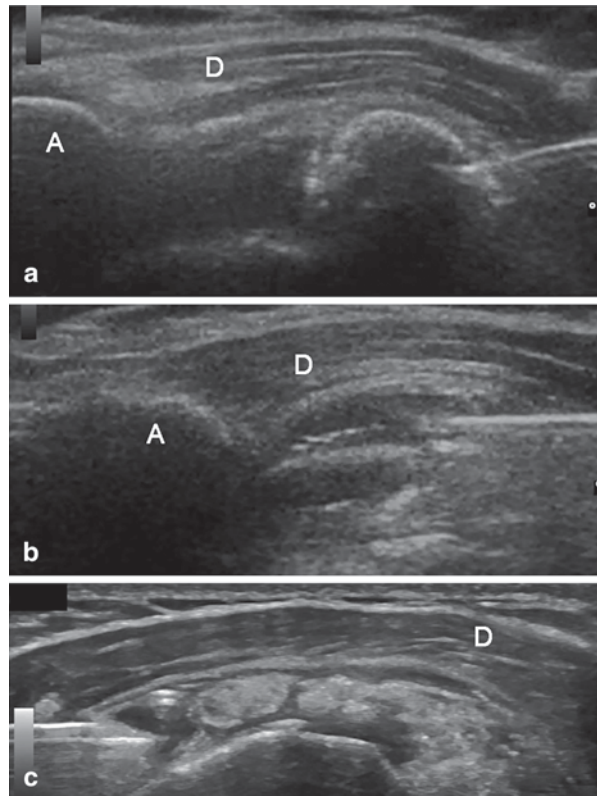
Supraspinatus tendon calcifications: a US-guided needling followed by b corticosteroid injection of the subdeltoid bursa; c aspiration of a cystic calcification. *US* ultrasonography
